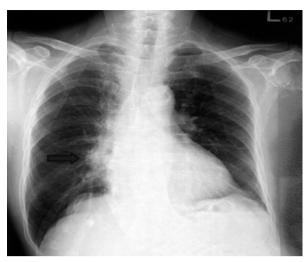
Chest X-ray (February 2012) revealed a soft-tissue shadow at the right lower lung, near the right hilum (as arrow indicates)
